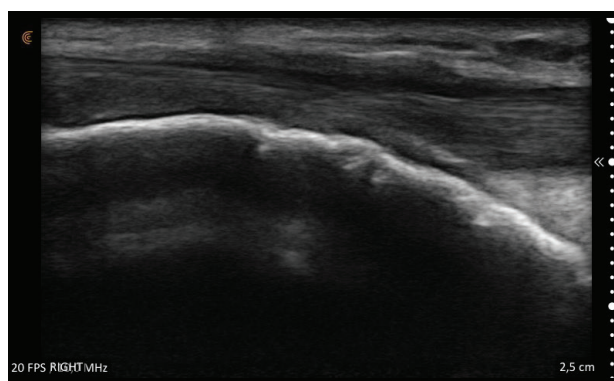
Ultrasound picture of the same right knee from a slightly different angle, 3 months after the three injections. Visibly less ossifications and deformations.
